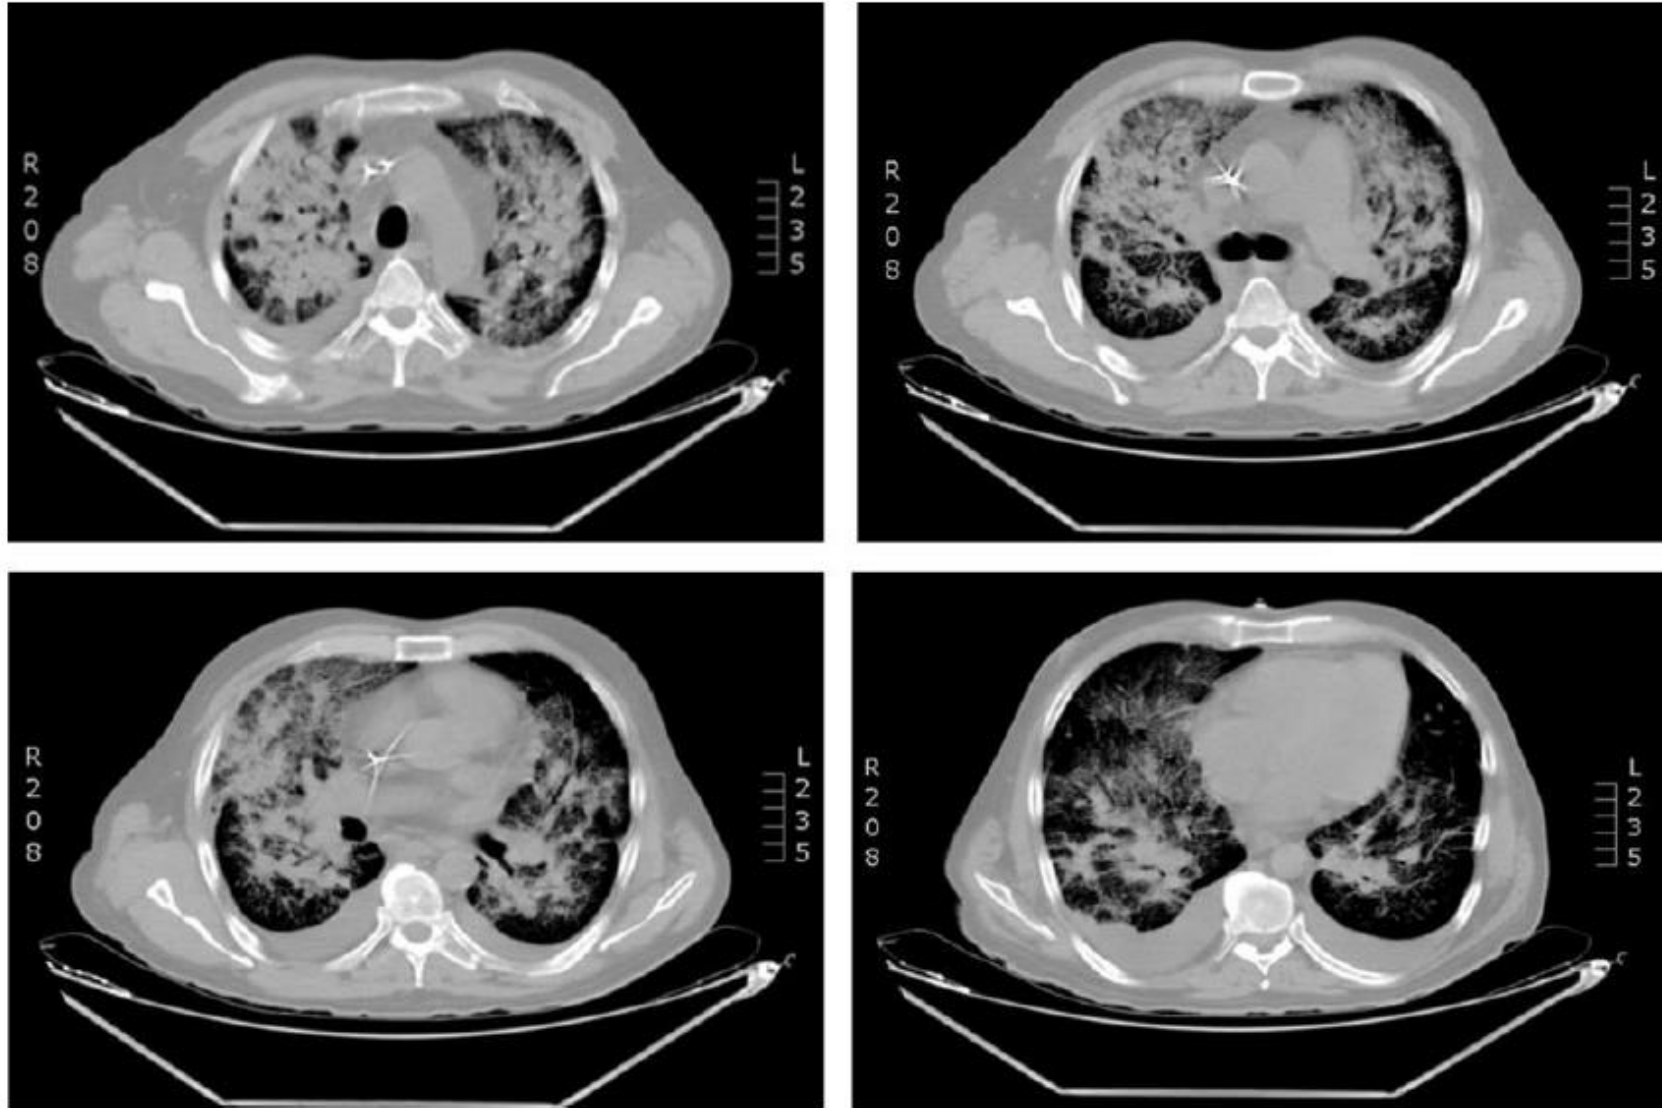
Computed tomography (CT) scan of the chest revealing bilateral bronchopneumonia
